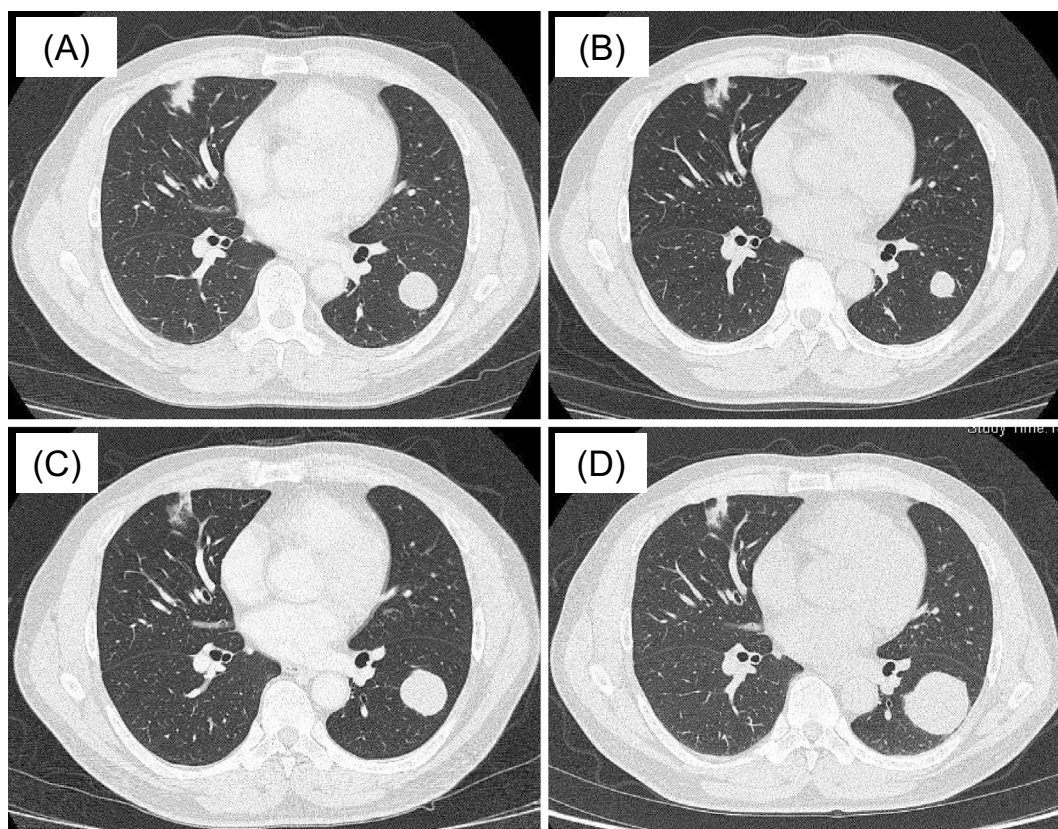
Chest computed tomography findings. (A) At the initial visit. A nodule, which was 23 mm in diameter, was seen in the left lower lobe (S⁸). (B) One month after the initial visit, the nodule spontaneously regressed (from 23 to 18 mm in diameter). (C) Two months later, the nodule showed re-growth (from 18 to 32 mm in diameter). (D) At the time of thoracic surgery, the nodule had further grown.
